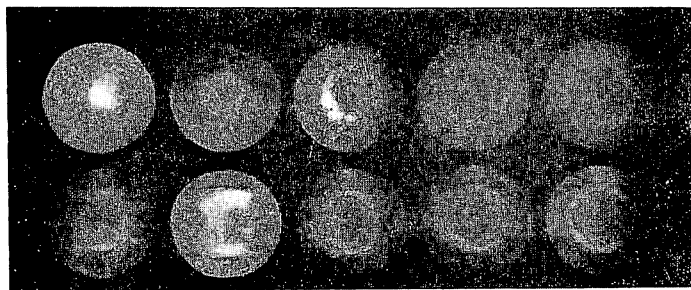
Rotatory Cross Section Radiogram (top), showing no distortion of the X-ray image, and tomogram (bottom), showing distortion of the X-ray image of a beeswax cavity encircled with thin wall
